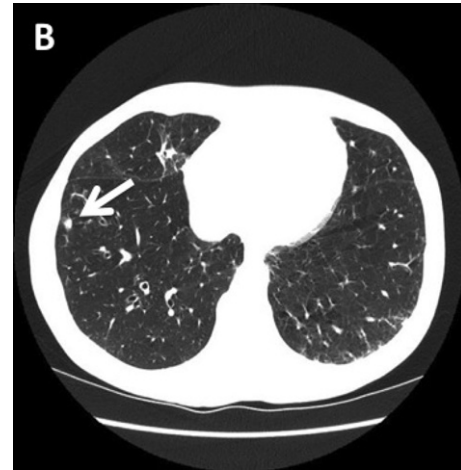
CT-scan; the arrow shows a nodular lesion in the right lower lobe, with mild bronchiectasis; “tree-in-bud” aspect of bronchiolitis in the left lower lobe.
